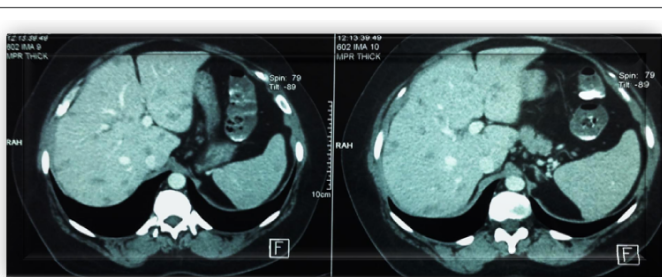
Abdominal computed tomography scan showing diffuse hepatic hypodense lesions.
